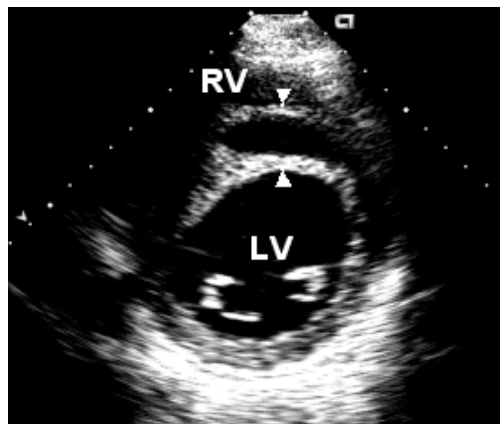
Parasternal short-axis view during systole showing LV cavity with a dissected interventricular septum (arrowheads).
